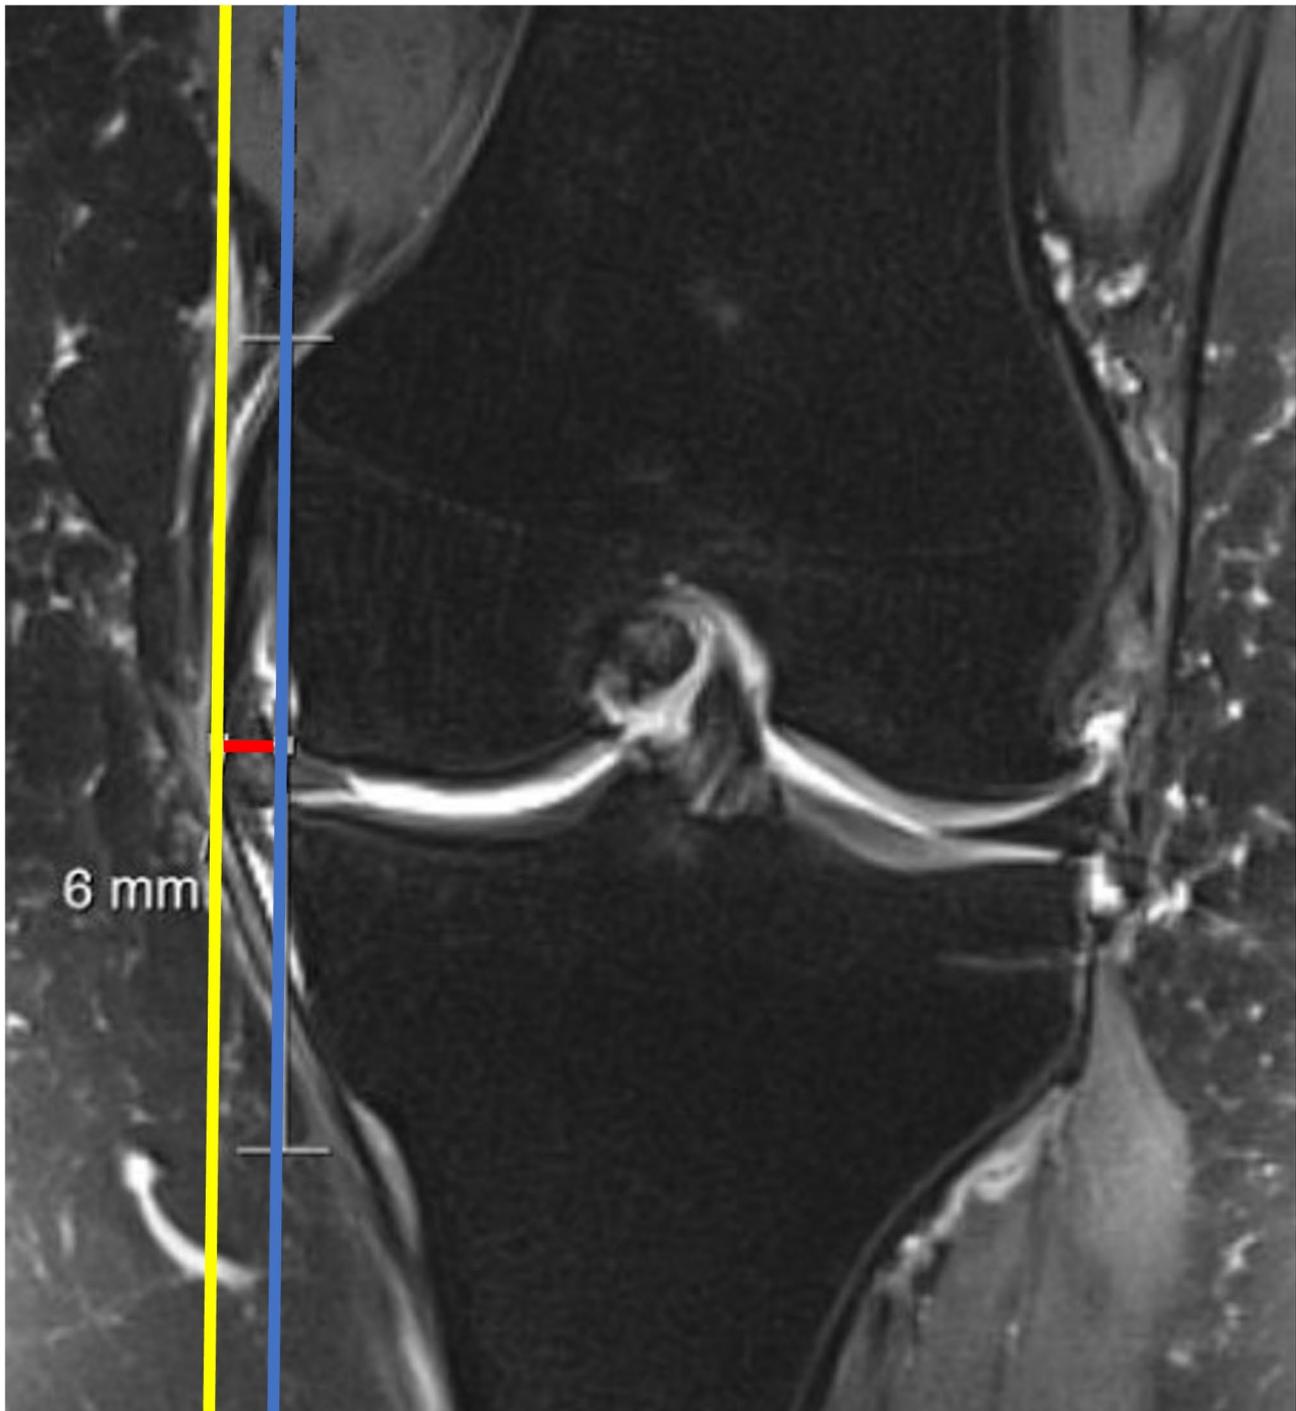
Measurement of medial meniscus extrusion of the left knee. On a proton density-weighted coronal magnetic resonance imaging section, the medial tibial spine apex was detected. A blue line was drawn at the outer margin of the medial tibial plateau. A yellow line was drawn at the outer margin of the meniscus. The distance between the blue and yellow lines was the MME (red line)
